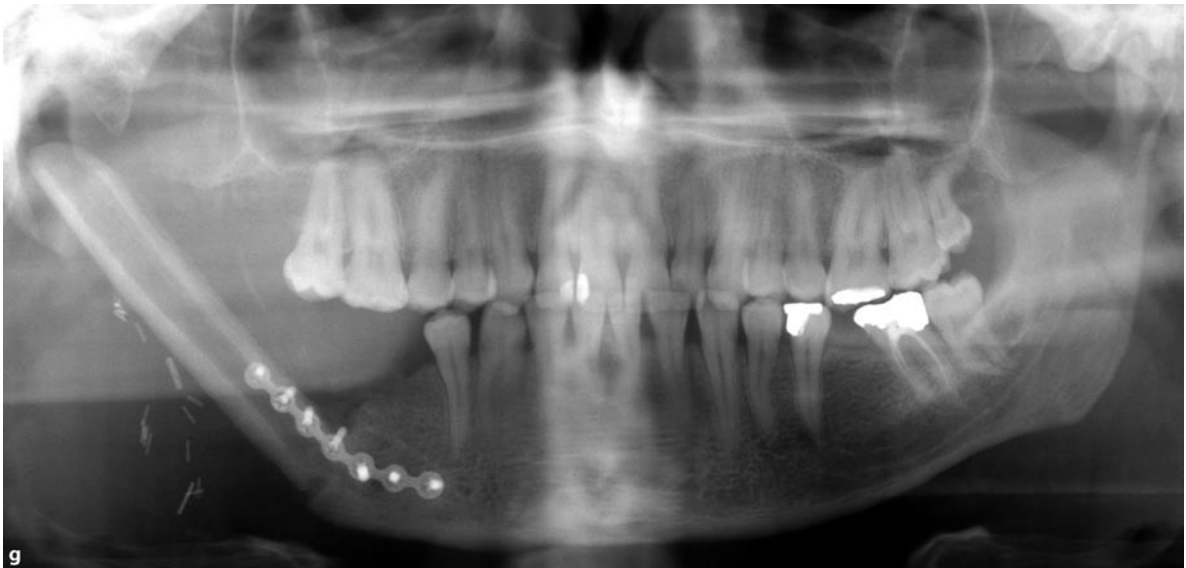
Patient at initial presentation with painful swelling of the right mandible up to the preauricular region and trismus with limited mouth opening of approximately 25-mm intercanthal distance (a,b). A CT scan (coronal view) of the patient at initial presentation (c). The right
